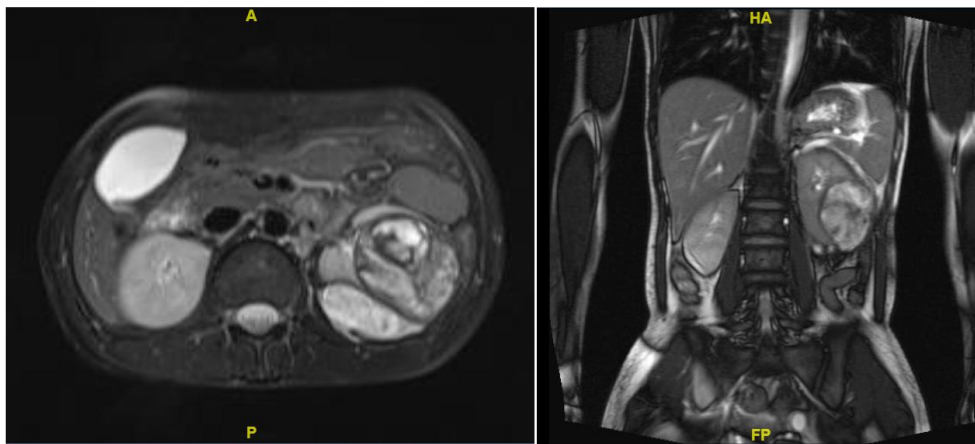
MRI abdomen coronal and transverse images depicting renal lesion in middle and lower pole of the left kidney.
